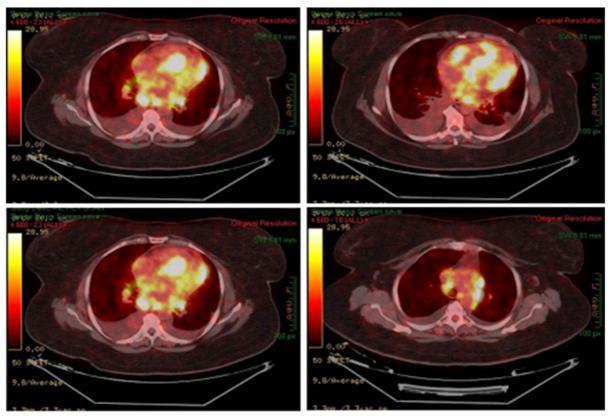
PET/CT shows diffuse 18FDG uptake in the mediastinum, septum and left ventricle.
